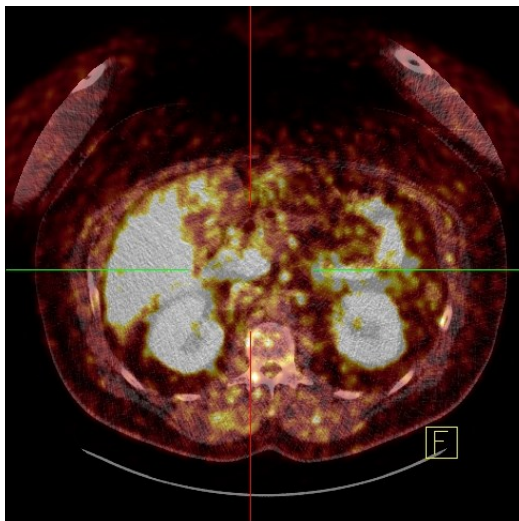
High physiological tracer uptake in PET/CT
